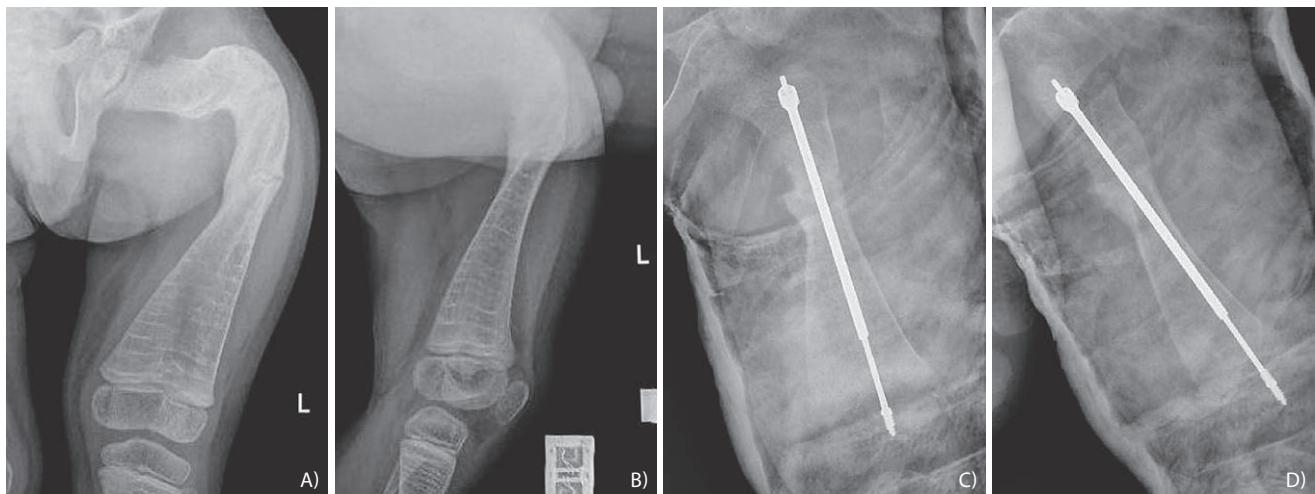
Preoperative radiograph of the left femur, anteroposterior view (A); preoperative radiograph of the left femur, lateral view (B); postoperative radiograph of the left femur, anteroposterior view (C); postoperative radiograph of the left femur, lateral view (D).
